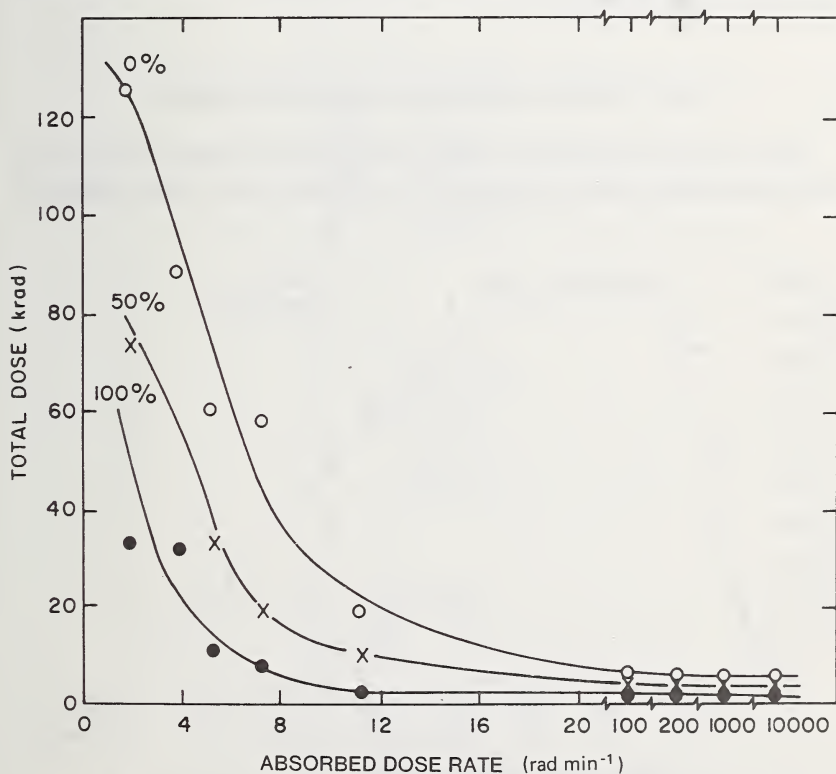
Production of *Saintpaulia* plantlets per leaf, as a percentage of control, after various x-ray doses and dose rates (From Broertjes, 1972).
